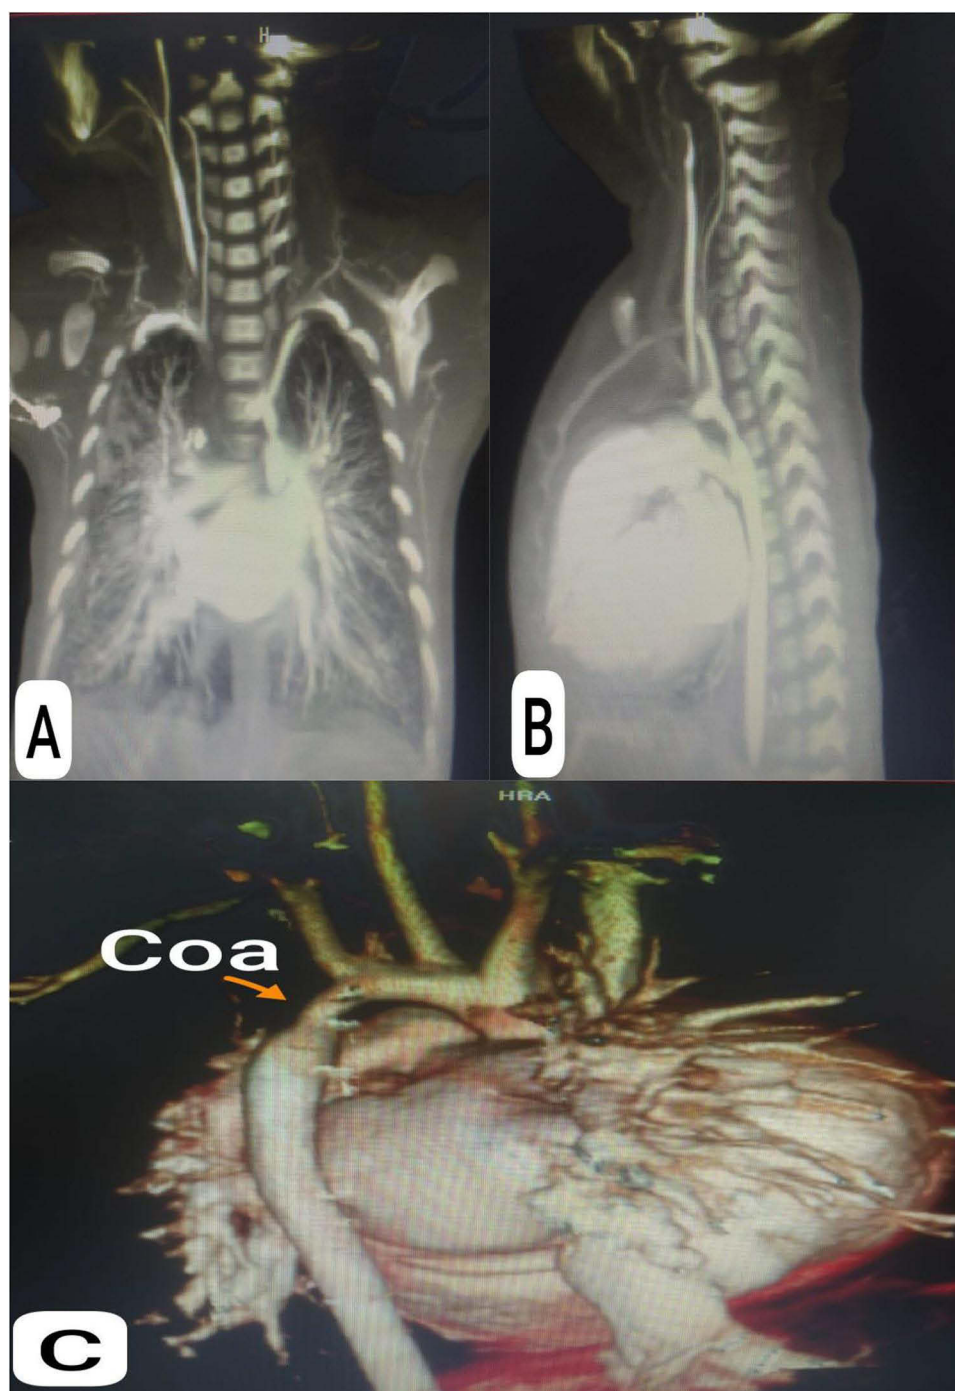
(A and B) Computed tomography angiography demonstrating a large membranous VSD and coarctation at the outlet of the descending thoracic aorta. (C) high-resolution MSCT images demonstrating a combination of congenital anomalies.
